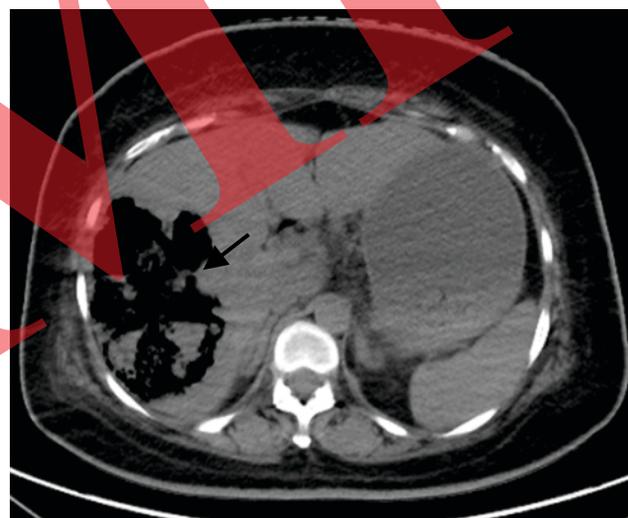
b) CT abdomen shows Emphysematous liver abscess
